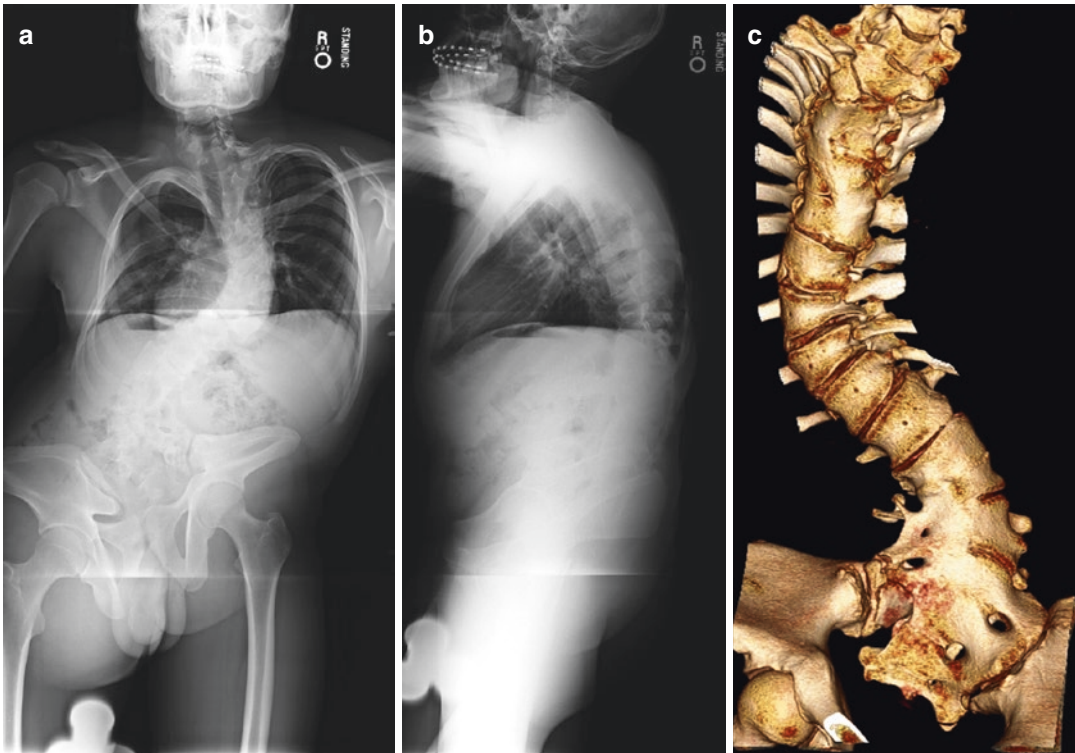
(a) Anterior-posterior whole spine radiograph of a 17-year-old boy with VATER association showing severe congenital scoliosis with coronal plane imbalance. He also had a history of tethered cord release at 16 years of age. (b) Lateral view of the whole spine showing
